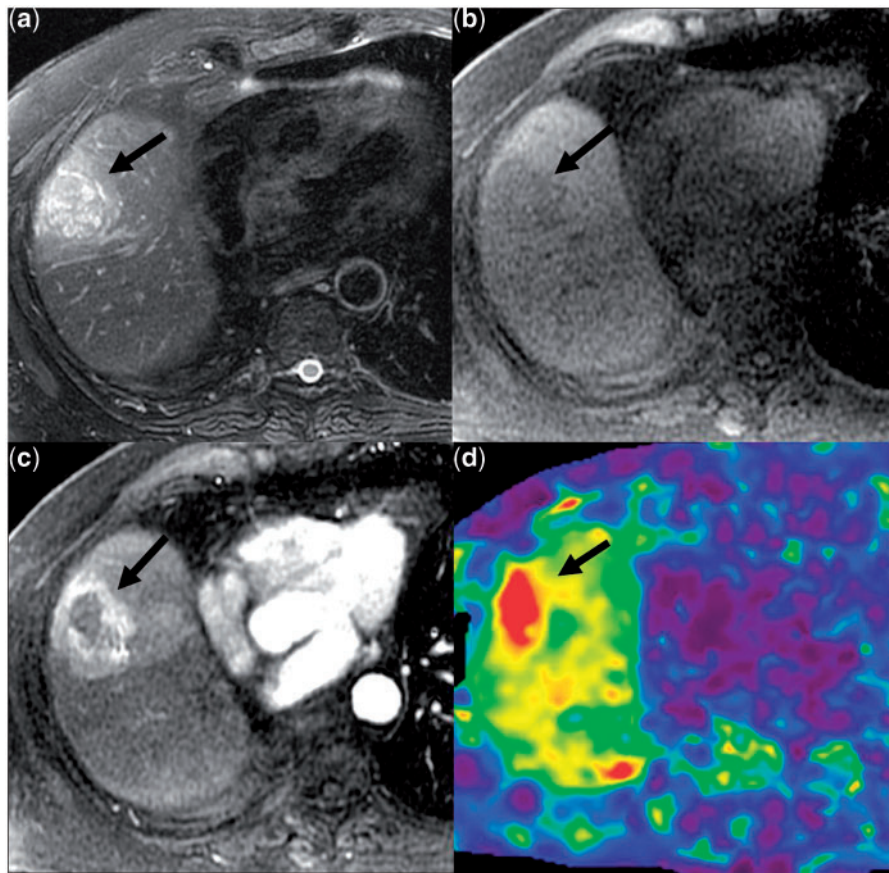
MR elastography of HCC in a background of cryptogenic liver cirrhosis. T2-weighted (a), unenhanced T1-weighted (b) and arterial phase (c) T1-weighted images showing typical HCC. Stiffness map from MR elastography (d) showing a high stiffness value of 10.6 kPa in the tumor. The stiffness of the liver parenchyma is 6.3 kPa, higher than the normal liver stiffness cut-off value of 2.93 kPa.
